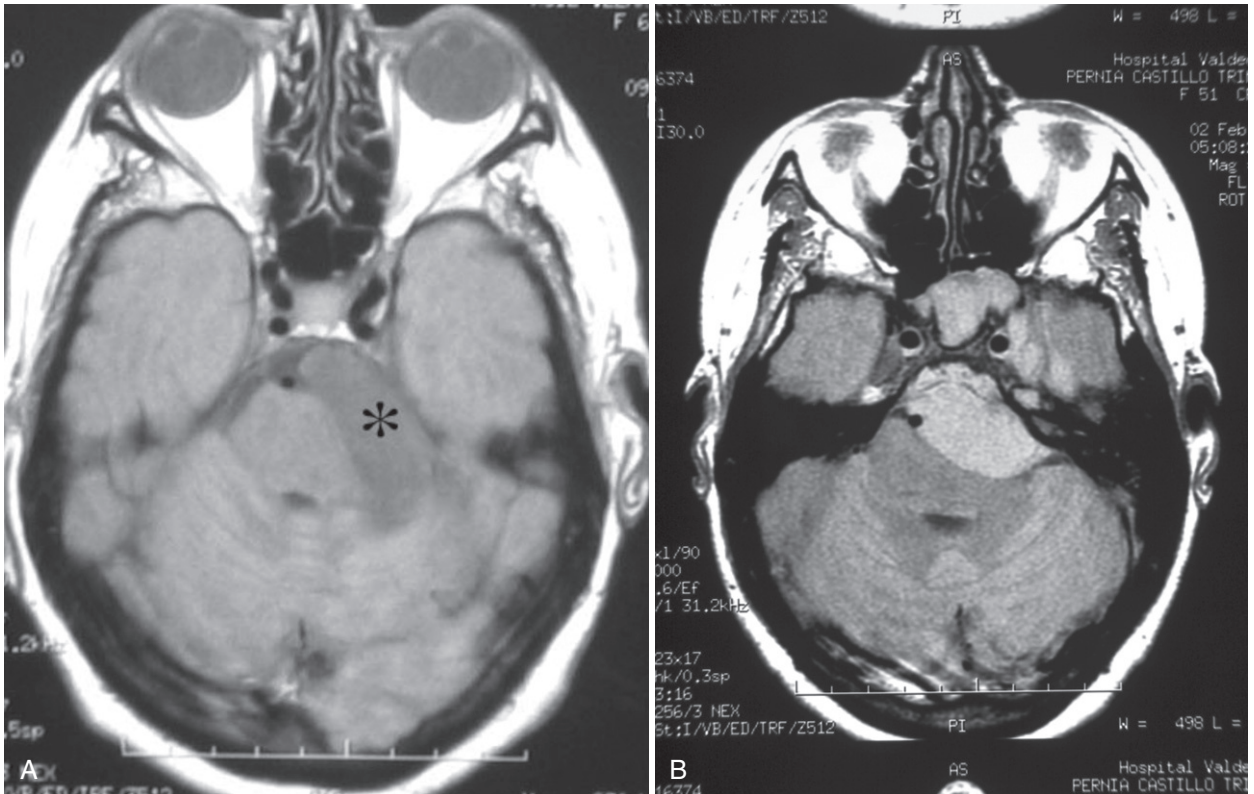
Magnetic resonance imaging scans of 2 patients presenting with cough headache showing posterior fossa dermoid tumor (A) and meningioma (B).
